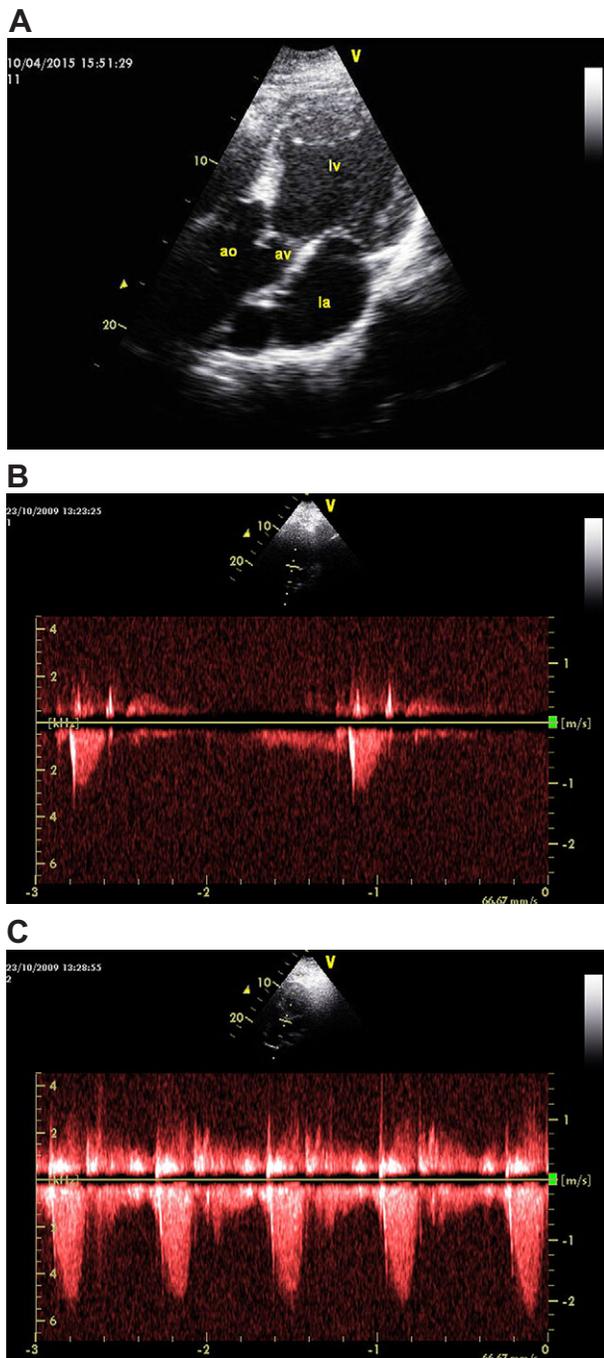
Transthoracic ultrasound data before and after exercise. (A) Two-dimensional axis view of the dolphin heart showing the aorta (ao), aortic valve (av), left atrium (la) and left ventricle (lv). (B) Aortic continuous flow ultrasound during rest [stroke volume (SV) 122 ml, cardiac output (CO) 4400 ml min⁻¹] and (C) 1 min after exercise (SV 240 ml, CO 22,490 ml min⁻¹), both measured at the second half of the inter-breath period.
